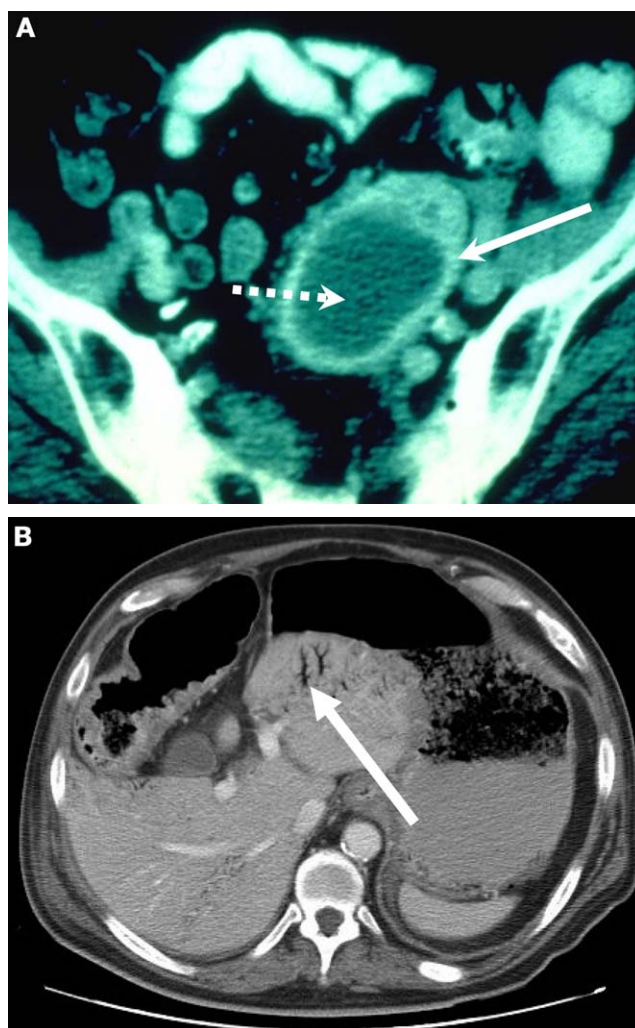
CT findings in intra-abdominal infection. 1a, CT scan showing a localized abscess secondary to perforated diverticulitis. Note rim enhancement of abscess wall (solid arrow) and inhomogeneity of abscess contents, with focal pockets of air (dashed arrow). 1b, Intestinal ischemia secondary to a low flow state following complicated cardiac surgery; features of ischemia include pneumatosis (air in the gut wall) involving the stomach and transverse colon, and air in branches of the portal vein to the left lobe of the liver (white arrow).
